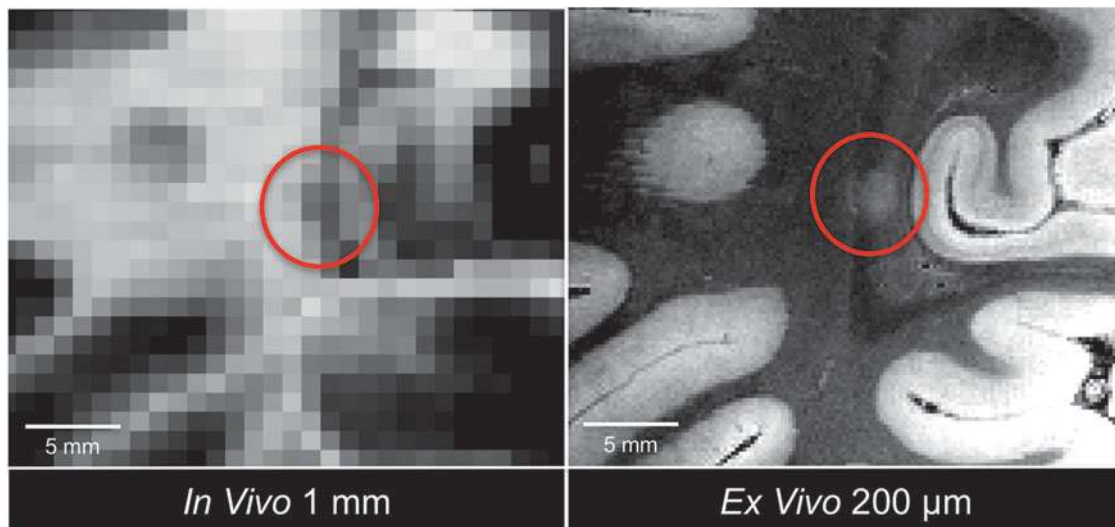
Co-registration-based lesion localization on *in vivo* magnetic resonance imaging (MRI). Using combined volume- and surface-based co-registration (as shown in Fig. 7), the punctate hyperintense lesion seen in the occipital white matter on the *ex vivo* MRI dataset (red circle, right panel) is colocalized to its precise anatomic coordinates in the *in vivo* MRI dataset (red circle, left panel). The *ex vivo* MRI dataset used in the co-registration was the flash20 parameter map synthesized from the multi-echo flash 7 Tesla acquisition (200 μm spatial resolution), and the *in vivo* dataset was the T1 multi-echo Magnetization Prepared Rapid Acquisition Gradient Echo dataset (1 mm spatial resolution). Although no lesion was detected in the occipital white matter during the initial review of the *in vivo* MRI dataset, there appears to be a punctate hypointensity on the *in vivo* MRI dataset (red circle, left panel) that was only appreciated after the co-registration procedure. This observation suggests that *ex vivo* MRI may reveal lesions that were initially undetected on *in vivo* MRI. Color image is available online at www.liebertpub.com/neu
